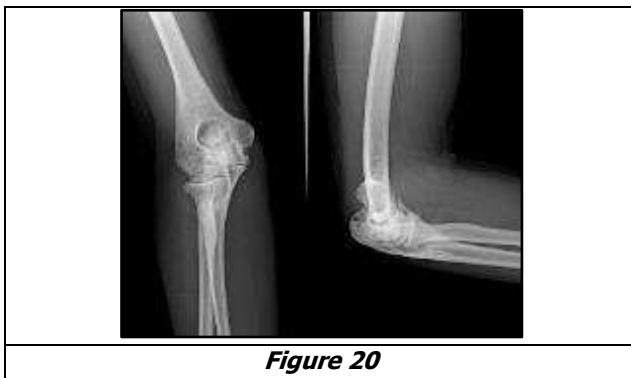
shows enlarged radial head, prominent radial notch of ulna, joint space narrowing, early subchondral cyst formation and periarticular osteopenia seen in the AP and lateral radiographs of right elbow in a 32 yrs. old haemophilic patient.
